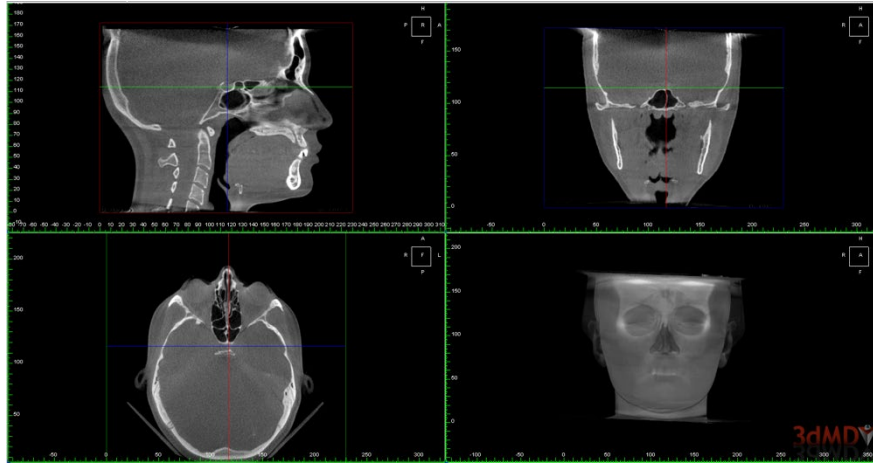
Determination of Sella point on CBCT
